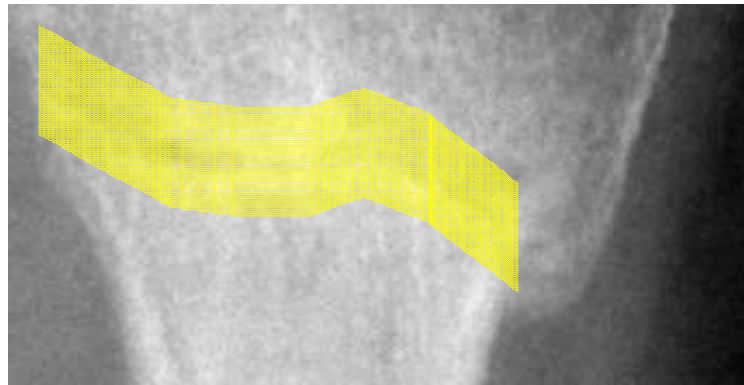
X-rays showing the ROI in the same patient marked in a) the first and b) the second AP X-ray, taken 28 days later.
